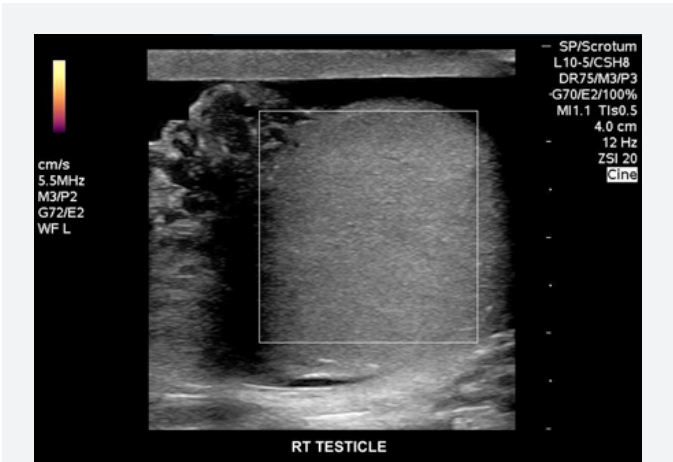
Power Doppler imaging fails to demonstrate perfusion.
